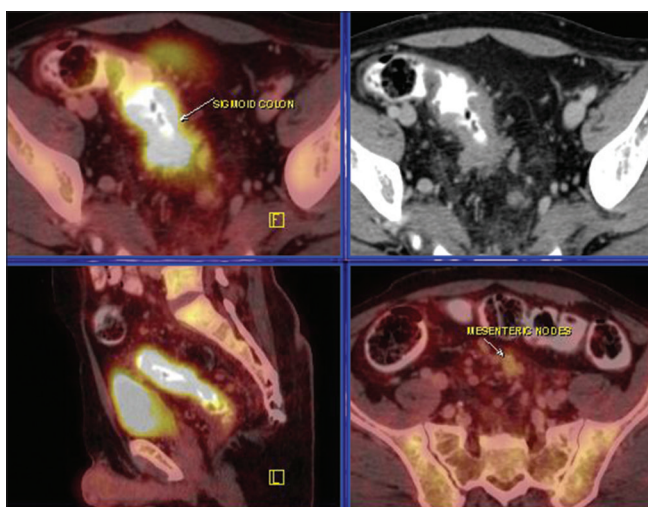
Fluorodeoxyglucose positron emission tomography-contrast-enhanced computed tomography images show fluorodeoxyglucose-avid primary rectosigmoid malignant wall thickening with few inferior mesenteric metastatic lymph nodes
